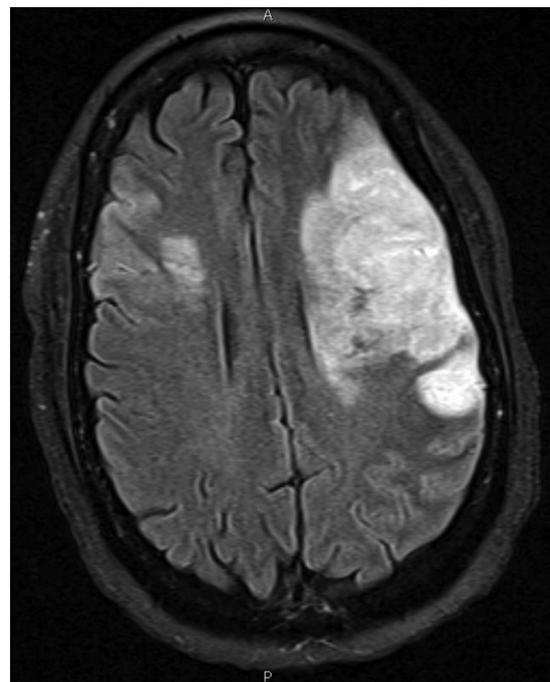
Diffusion-weighted MRI of the brain demonstrates restricted diffusion in the left middle cerebral artery vascular distribution consistent with evolution of infarction. New patchy areas of restricted diffusion can now be seen in the left thalamus, right caudate head, and right anterior middle cerebral artery vascular territory.
